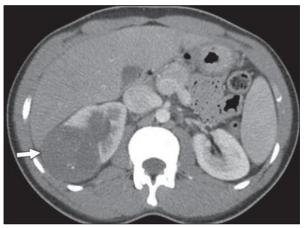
Axial contrast-enhanced CT image of abdomen obtained at presentation shows hypoattenuated right renal mass containing punctate calcifications [13]
